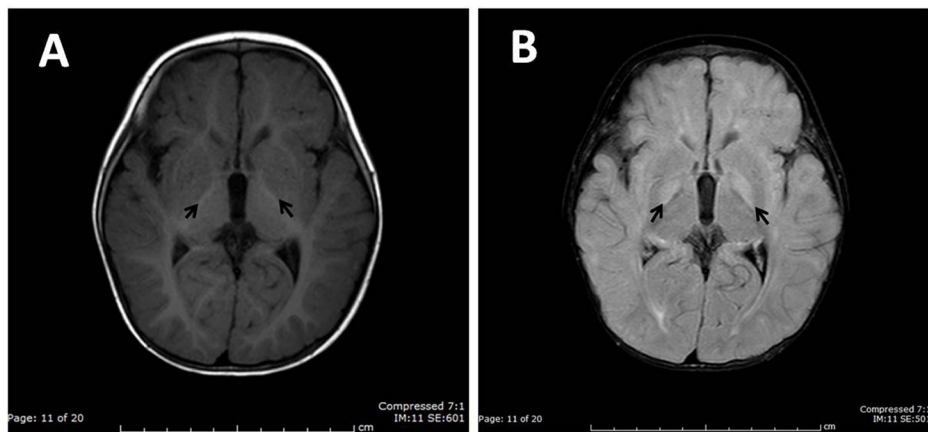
Brain MRI of a 1-year-old patient with history of bilirubin encephalopathy. Axial T1WI shows symmetrical isointensity in bilateral globi pallidi (A). Axial FLAIR image shows symmetrical hyperintensity in bilateral globi pallidi (B).
